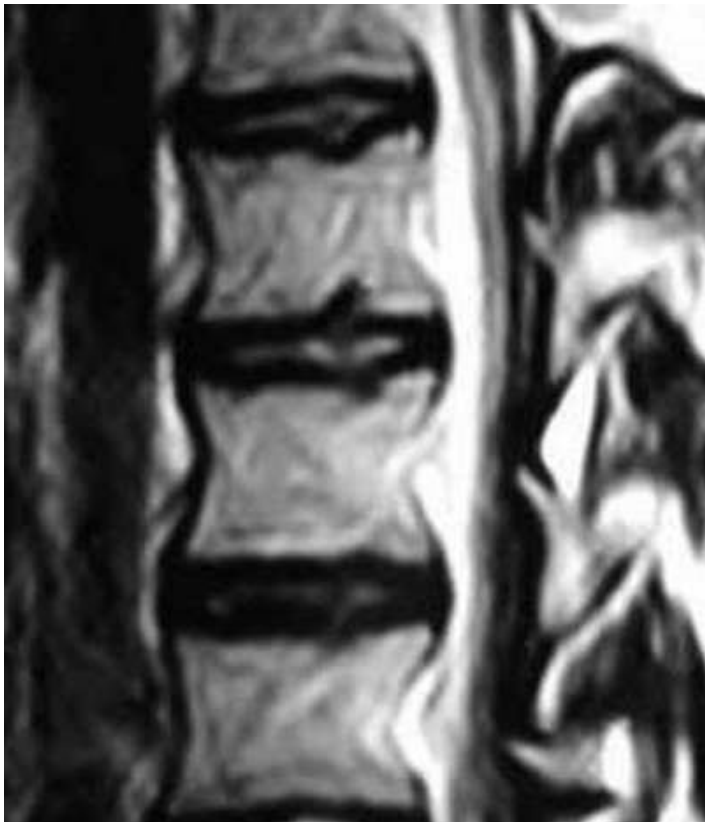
MRI T2 images of the lumbar spine (Sagittal view) showing reduction of the T2 signal of the upper lumbar discs denoting disc degeneration. Annular bulging is seen at L3-L4 and L4-L5. Notice the intranuclear cleft that transverse the equator of the disc between L4-L5. Also notice the vertical disc herniation (Schmorl's nodule) in the upper lumbar vertebrae.
